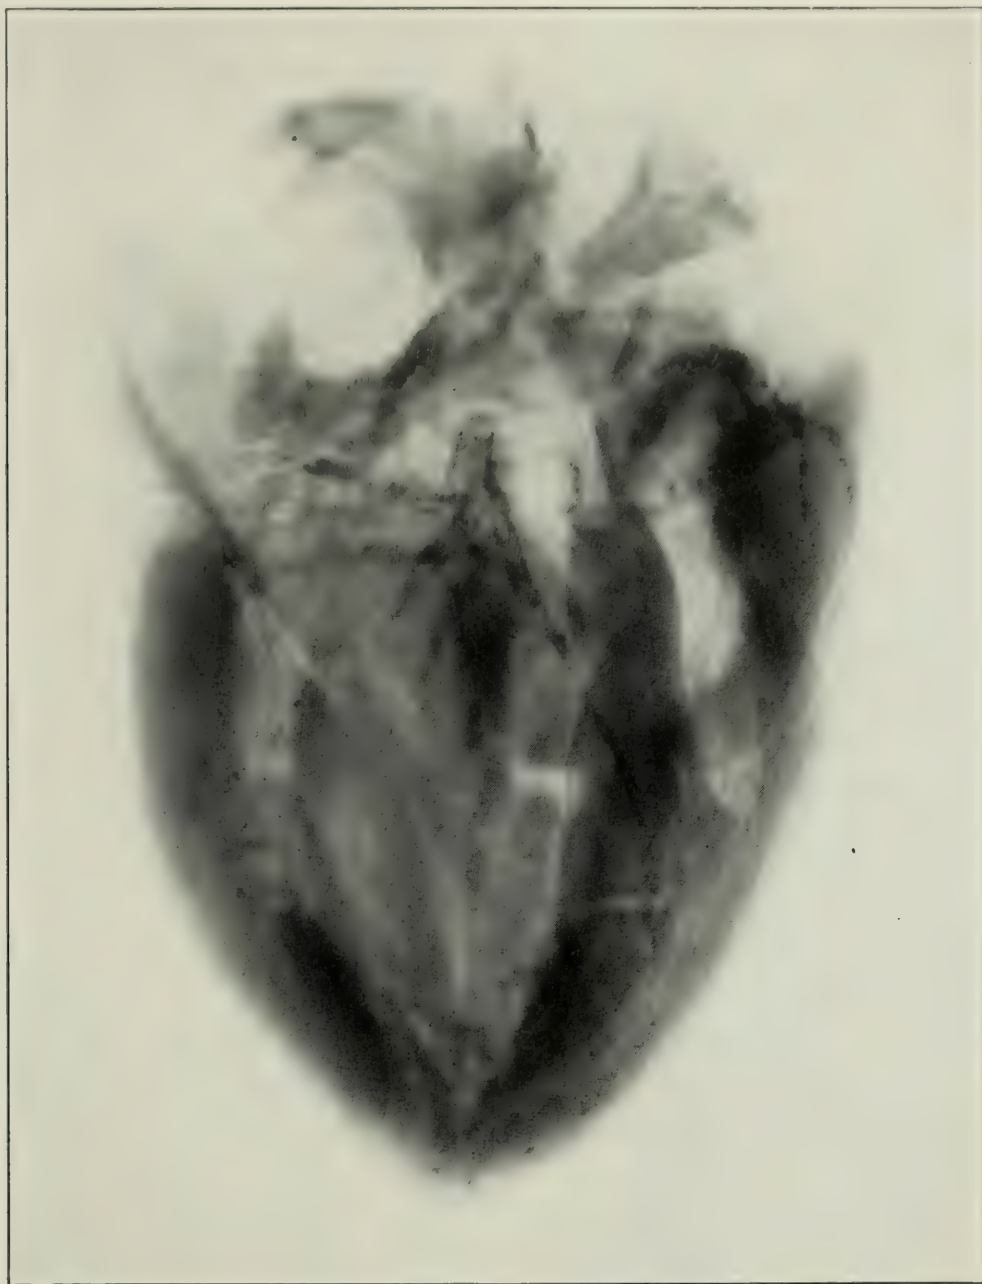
X-ray of heart: Extreme calcification of the coronary arteries (Autopsy 9112)
